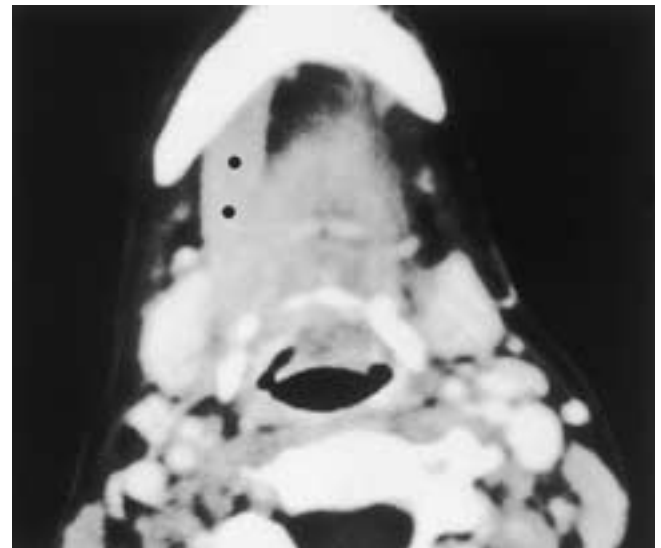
Digastric muscle aplasia. Axial CT scan demonstrates aplasia of the left anterior belly of the digastric muscle. The right digastric muscle is indicated by the dots.
